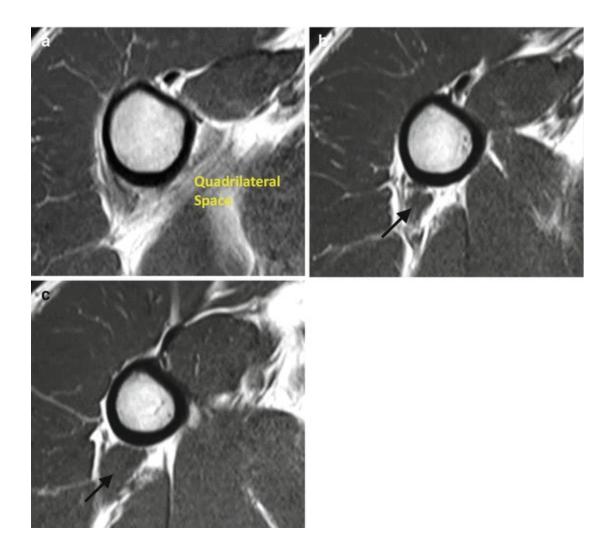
Insertion of the pectoralis major tendon and superior anatomic landmarks. Axial T1-weighted MRI show the quadrilateral space (a), the origin of the lateral head of the triceps (*arrow*, b, c) and the superior aspect of the tendon insertion (c).
